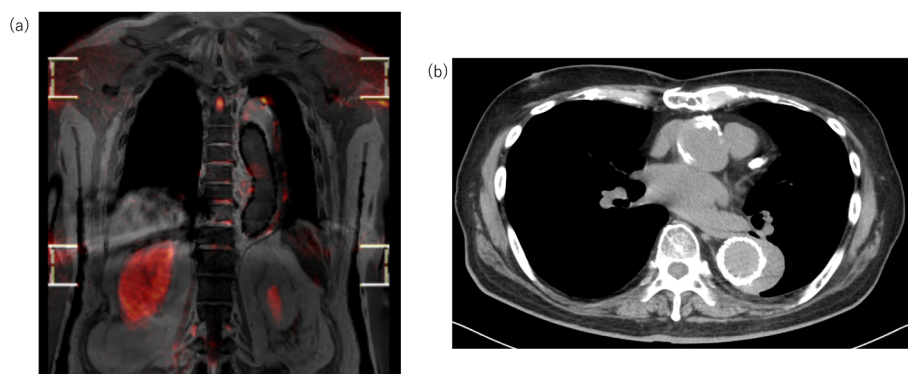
(a) Whole-body diffusion-weighted imaging with background body signal suppression at 57 days after admission. (b) Computed tomography at 4 months after discharge (maximum diameter was 46 mm).
